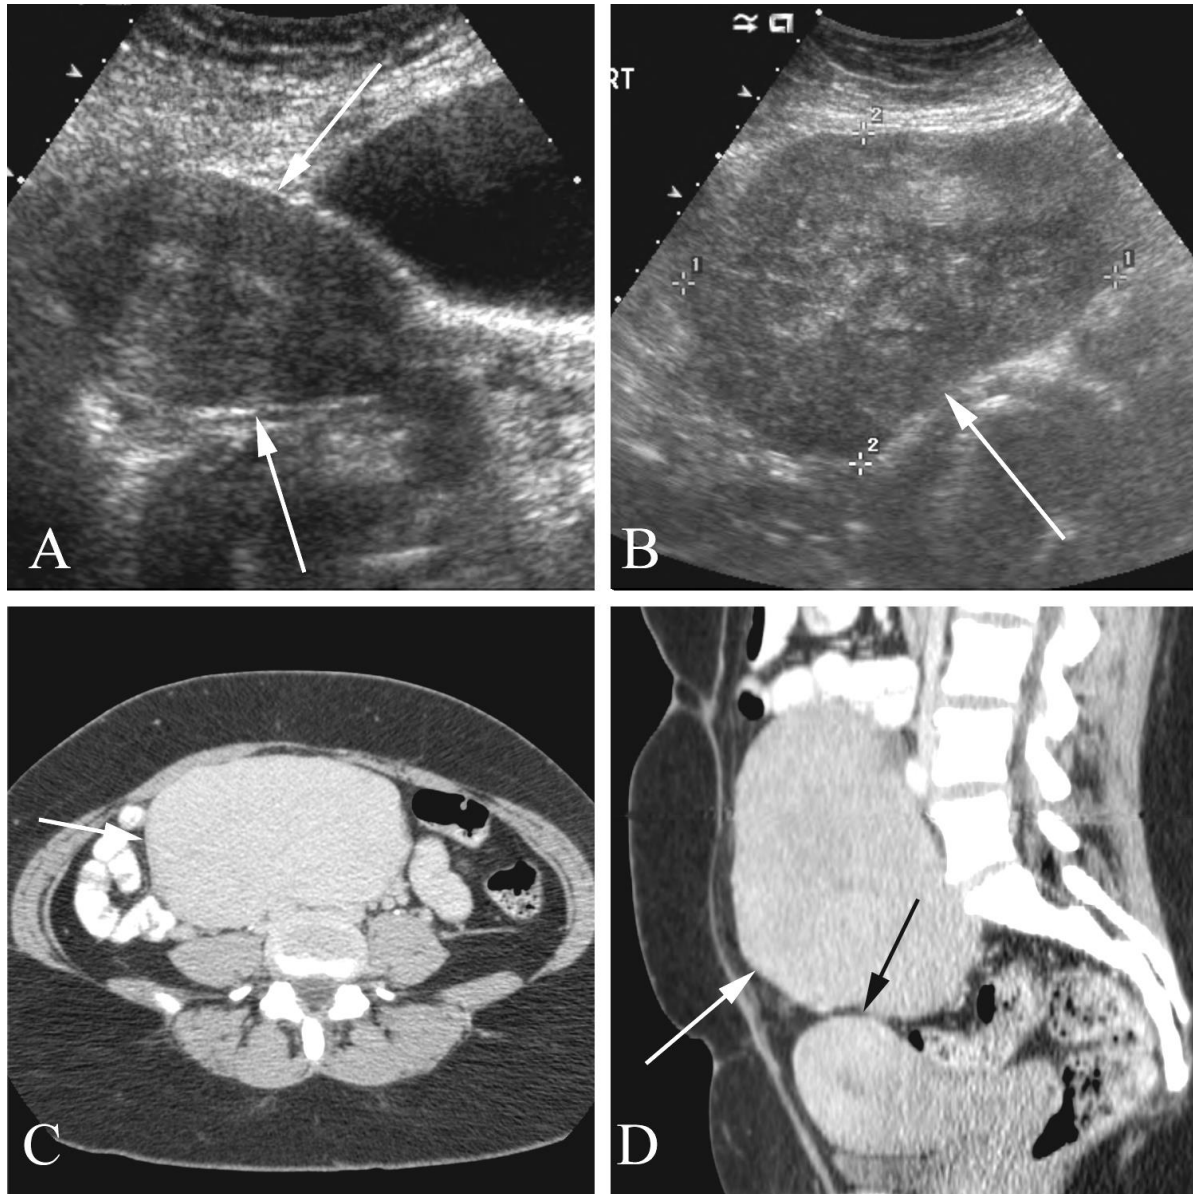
Extrauterine leiomyoma in a 40 year old woman with a lower abdominal and pelvic mass. US supplemented with CT to arrive at a diagnosis. A. Transabdominal US demonstrates a normal appearing uterus (arrows). B. Transabdominal US lateral and somewhat superior to the uterus demonstrates an isoechoic-to-hyperechoic mass (arrow) which had the texture of a fibroid. It was difficult to separate this lesion from the uterus. C. Axial CT study confirms a large, homogeneous mass of the lower abdomen (arrow). D. Sagittal reformatted image demonstrates the mass (white arrow) with a clear demarcation plane separating the mass from the patient's uterus (black arrow). CT-directed biopsy (not shown) was consistent with a leiomyoma. Subsequent surgical removal showed an extra uterine, intra-abdominal leiomyoma.
